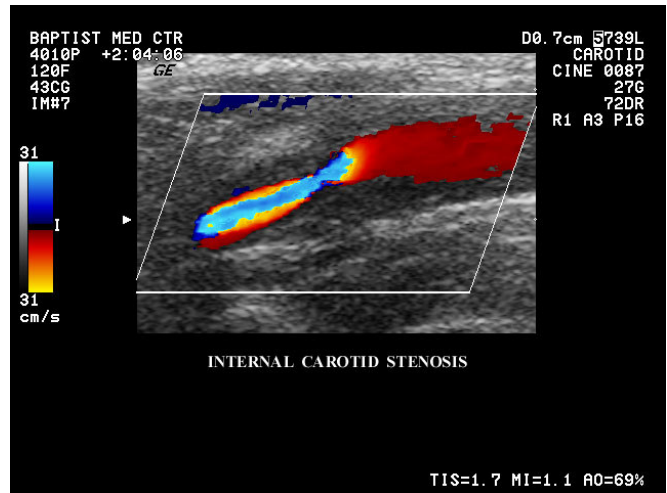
Color Doppler shows a longitudinal image of a patient with internal carotid artery stenosis. The internal carotid artery shows the area of narrowing with increased (aliased) flow denoted by the blue/yellow pattern. (Permission from GE Medical, copyright © GE Medical)
